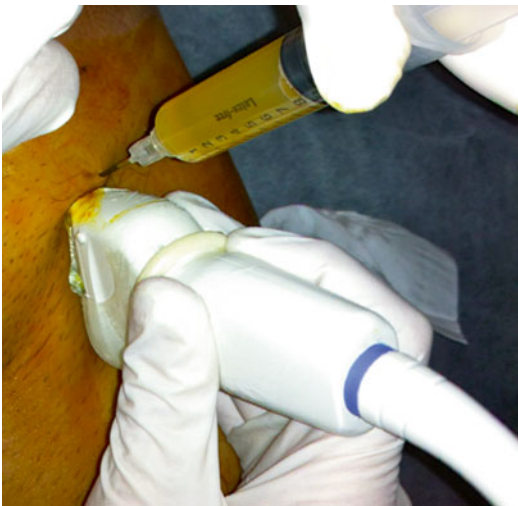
Hip. Application of PRGF-Endoret in the intracapsular hip space guided by ultrasound
